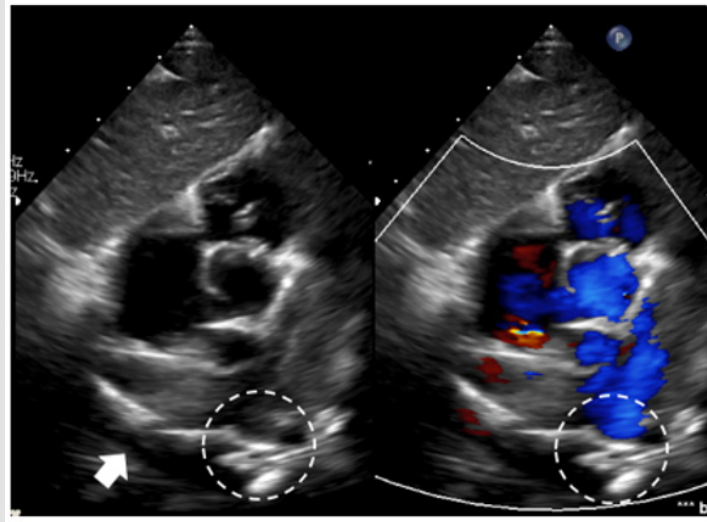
Echocardiogram 2D compare with color mode in Modified subcostal view showing the location and efficiency of filling, and the placement of the device beyond pulmonary sequestration (dotted line) in the area of the thoracic descending aorta (arrow) behind the heart. This is to check for side effects that may occur, which is the device protruded and blocked the blood flow in the aorta.
